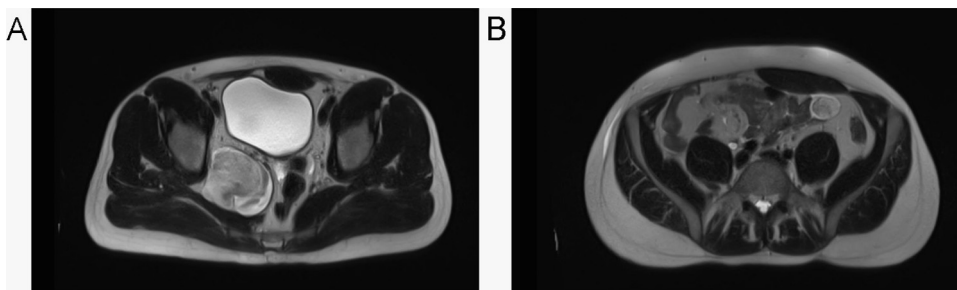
T2 abdominal and pelvic MRI with contrast on February 13th, 2015 revealed the previously known pelvic tumor (A) along with newly formed hypervascular mesenteric masses (B).
